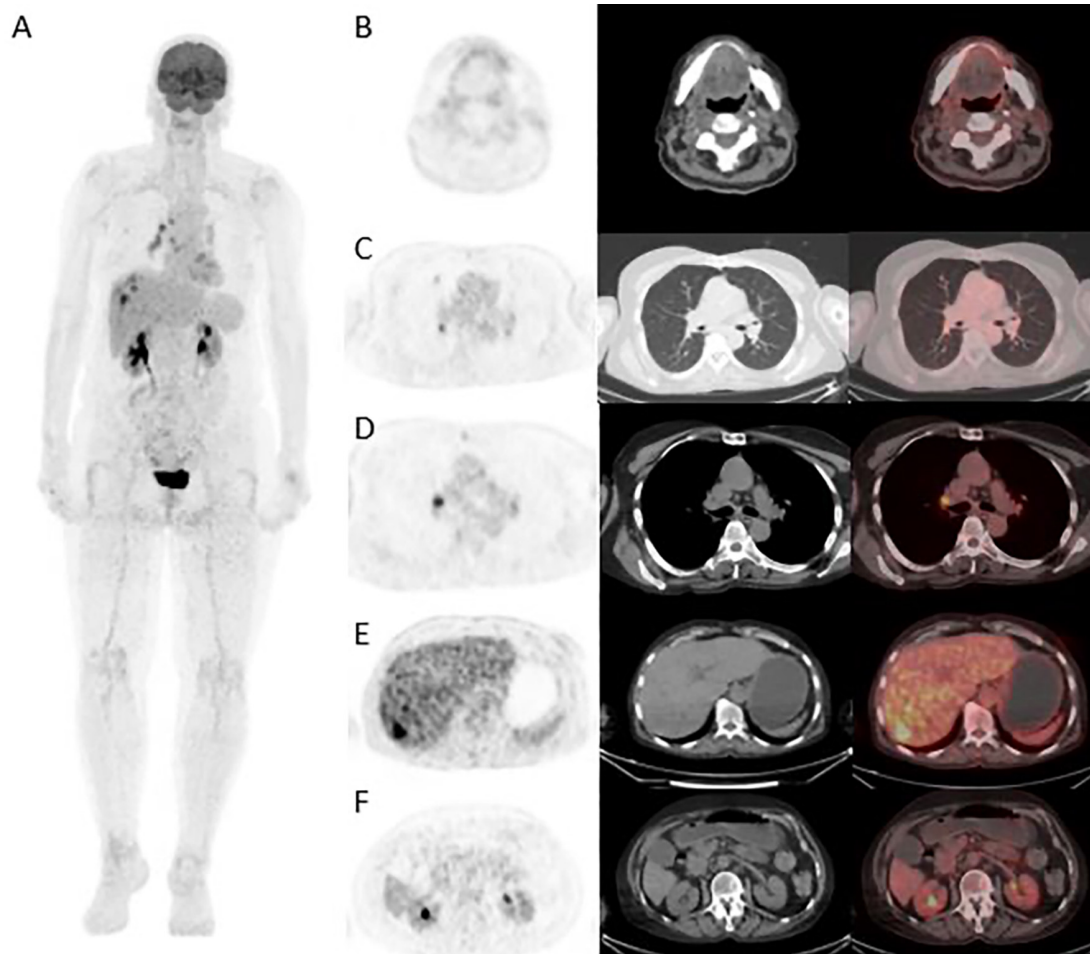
(A-F). Standard quadruple anti-tuberculosis (TB) therapy was initiated for the patient. After treatment, a partial response was observed in the hypermetabolic lesions in the liver and mediastinum identified on the pretreatment ^{18}F -fluorodeoxyglucose positron emission tomography/computed tomography (^{18}F -FDG PET/CT), while a complete response was observed in the remaining lesions.
